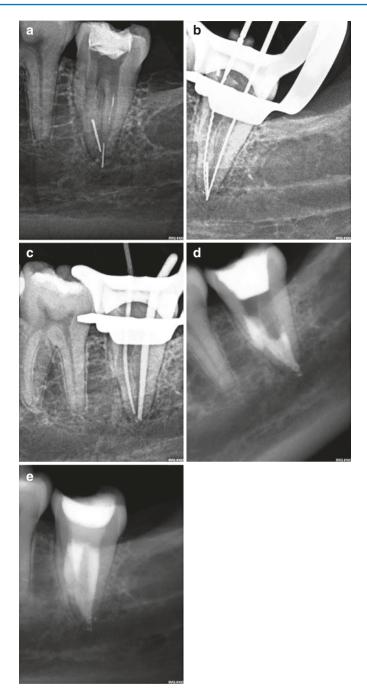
(a) Preoperative radiograph of a referred case with two fractured instruments. (b) Bypassing of the instruments and retrieval of one of the fragments with the file bypass technique, while the other, which became loose with the technique, was suctioned during sodium hypochlorite irrigation. (c) Pre-final radiograph with gutta-percha cones in place. (d) Immediate post-obturation radiograph. (e) Three-month recall radiograph (Courtesy of Dr. A. Chouliara)
